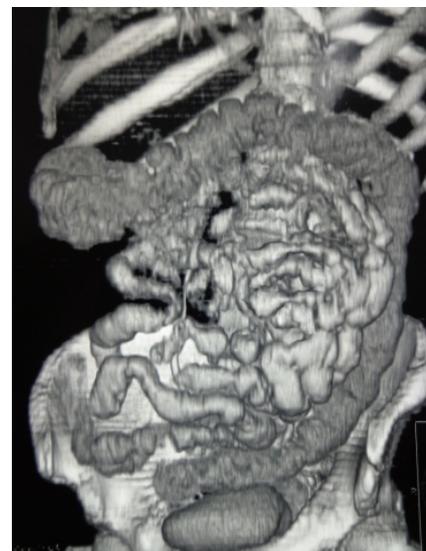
Abdominal CT scan with three-dimensional reconstruction showing an irregular colic thickening extended from right colon to the cecum.
